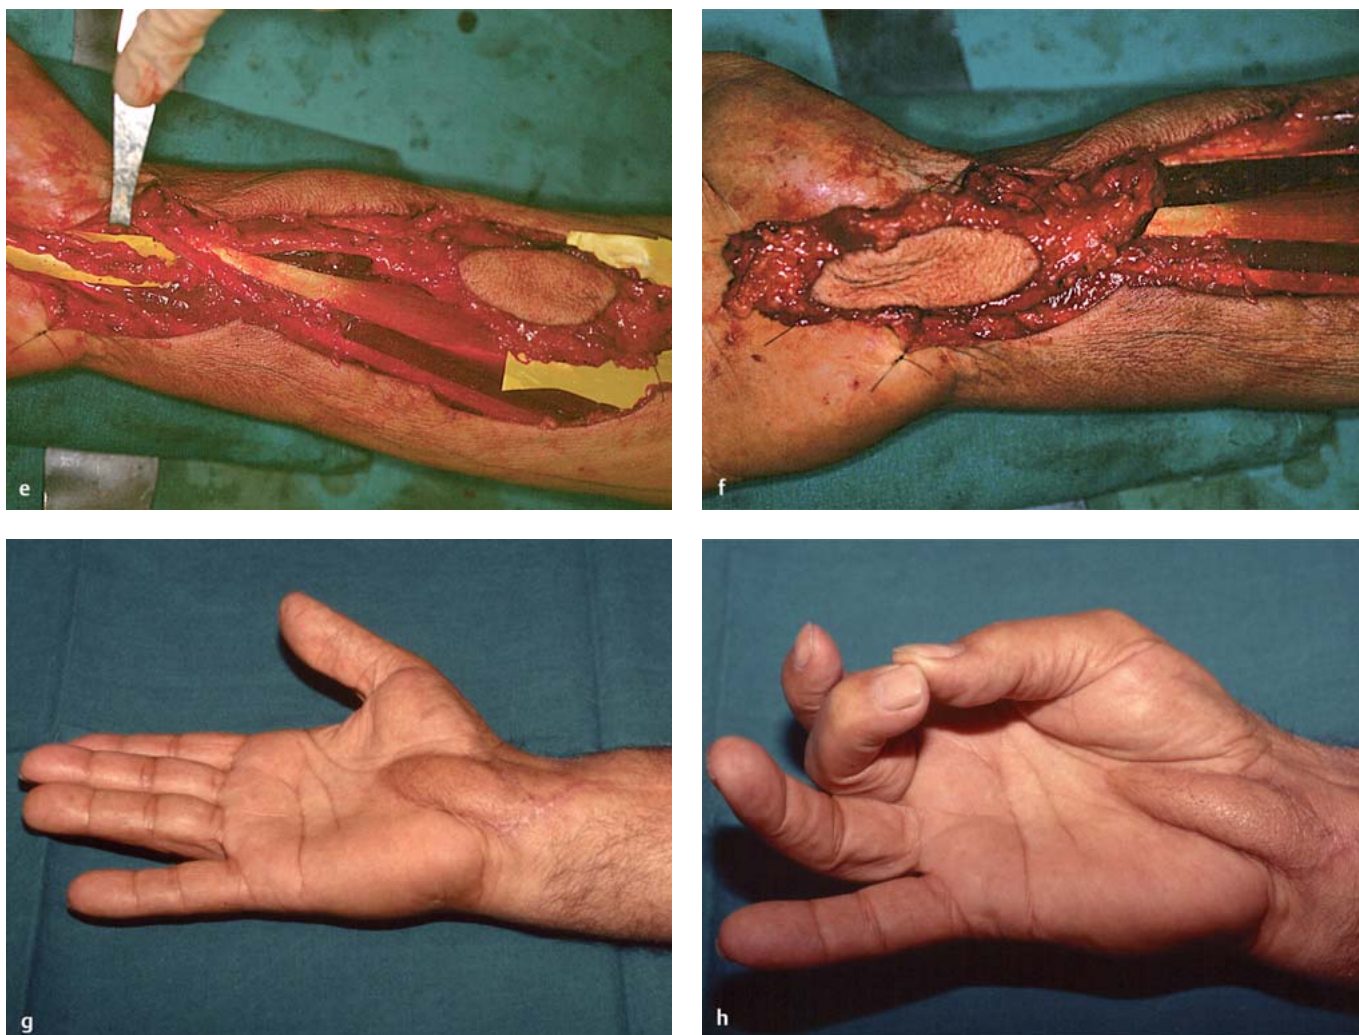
a to h a Male, 55 years old, with residual scarring (three arrows) after three OCTR operations. b Preoperative MRI image showing the median nerve scar adhesions. c Preoperative procedure planning. d The median nerve after the external neurolysis: it is evident the intr fascicular scar tissue with interruption and dislocation of the nerve fasciculi. e The radial island fasciocutaneous flap is harvested and (f) transferred to cover the median nerve. g, h Functional results at long term follow-up.
